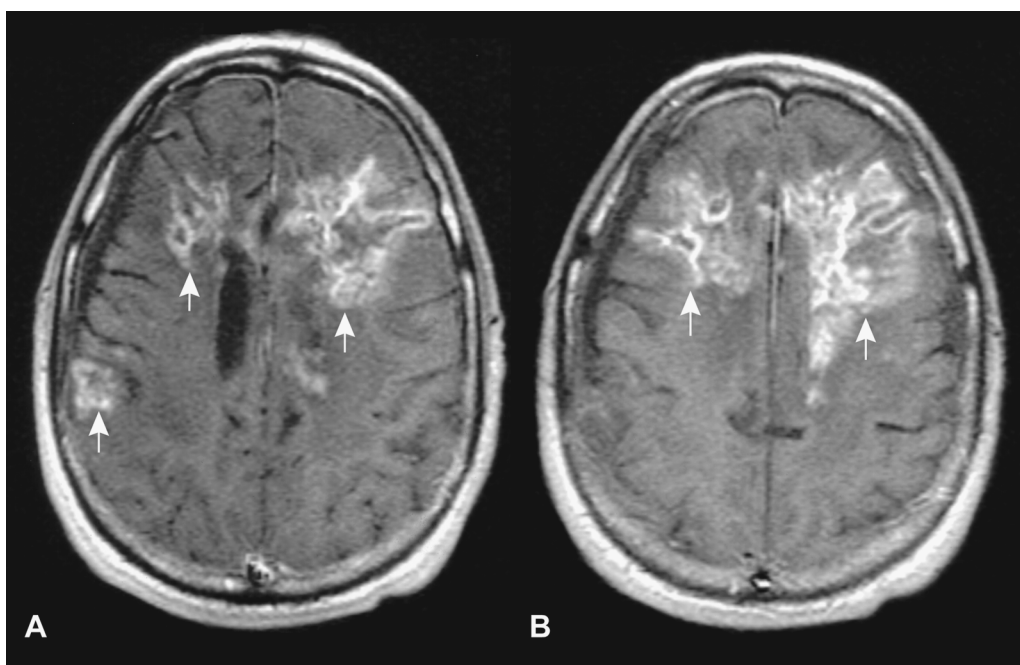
Post-contrast coronal T₁-weighted MR images (A,B) of the brain show extensive heterogeneous enhancing lesions involving both frontal lobes (arrows) with “Swiss cheese”-like interior, produced by radiation necrosis. Despite the large sized lesions, there is no mass effect secondary to involution of the brain. The patient was status postsurgery with accelerated radiation therapy and chemotherapy for a right frontal lobe anaplastic astrocytoma.
